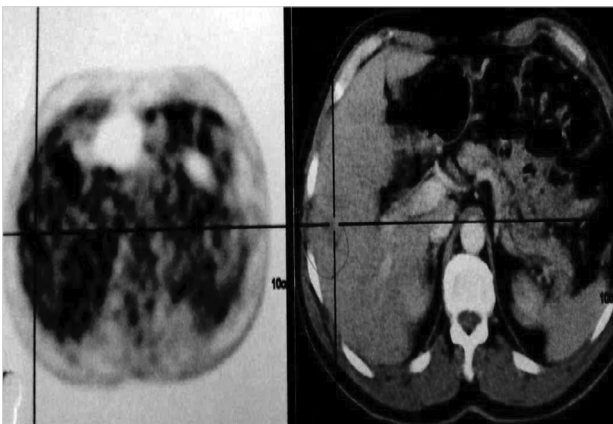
PET CT scan of the first patient: Heterogeneous moderate increased pathologic FDG uptake in the 5th-6th segments of the liver (Early SUVmax: 4.6, Late SUVmaks: 5.8). Interpreted as HCC
